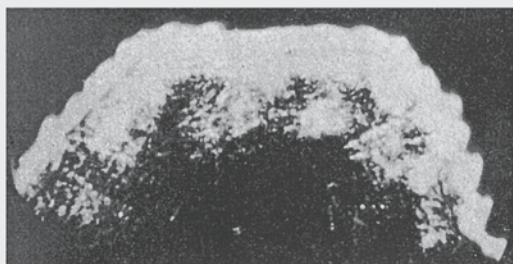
Gross ascites due to cirrhosis of liver. Ultrasonic beam can penetrate more deeply in random fashion because of fluid between coils of intestine.
